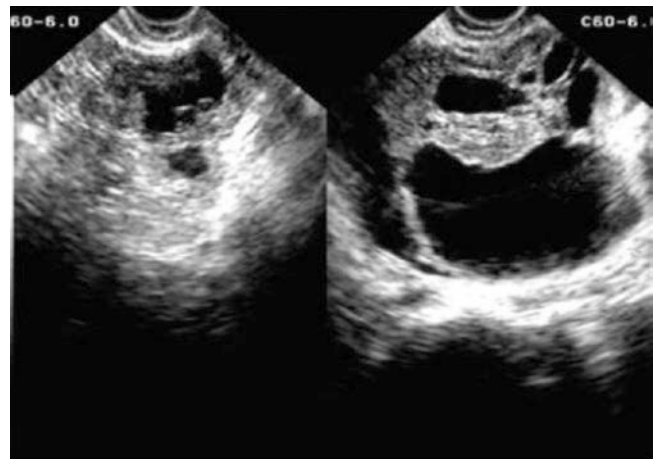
Pelvic inflammatory mass. Twenty days after an induced labor, the patient sees a doctor for lower abdominal pain. The sonogram shows the irregular cystic occupation with septum
